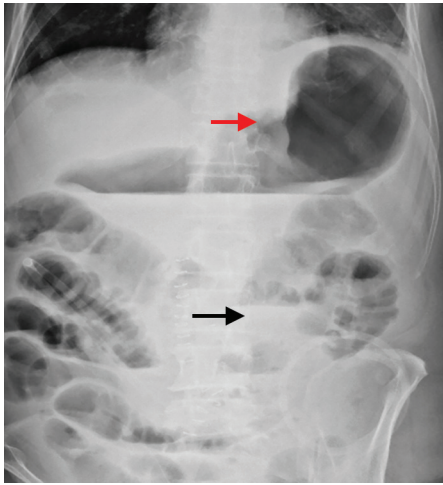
Plain X-ray of abdomen erect view (Red arrow – gastric dilatation, Black arrow – multiple air-fluid levels suggestive of ileus)
